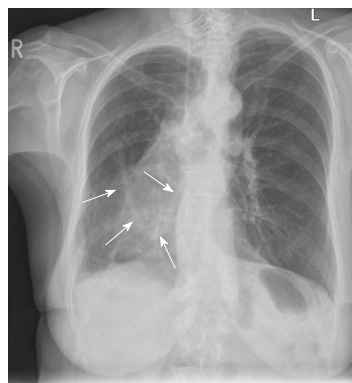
Posteroanterior chest X-ray demonstrating an anomalous curvilinear vessel (white arrows) running from the right mid zone inferomedially before turning superiorly. There is loss of volume within the right hemithorax and mediastinal shift to the right suggesting cardiac dextroposition. L: Left; R: Right.
